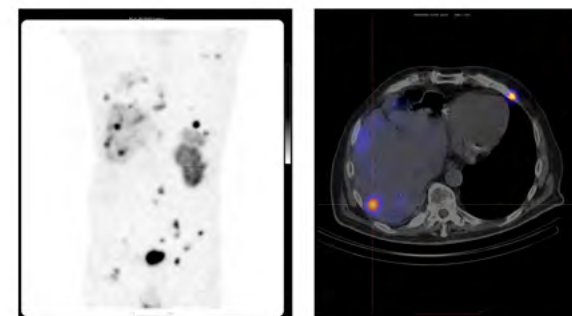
Metastatic neuroendocrine neoplasm, somatostatin receptor imaging with $^{99\text{m}}\text{Tc-EDDA/HYNIC-TOC}$. Multiple metastases are demonstrated throughout the body on the MIP image (left panel); SPECT/CT clearly localises the lesions and differentiates between liver and bone metastases.
